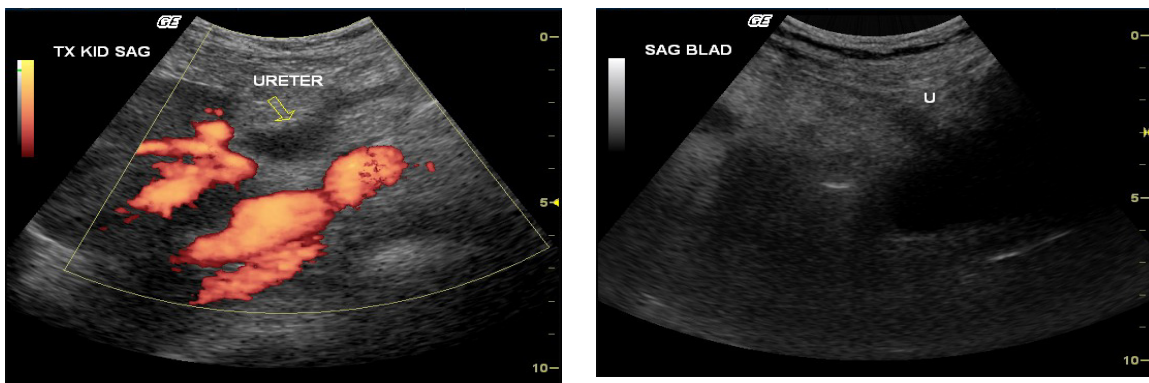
A and B: Normal transplant ureter. Image A, a Doppler image through the transplant kidney shows prominent proximal ureter (arrow) located relatively anteriorly. Image B, an US image through the bladder (B) shows transplant ureter (U), implanted high towards the bladder dome.
